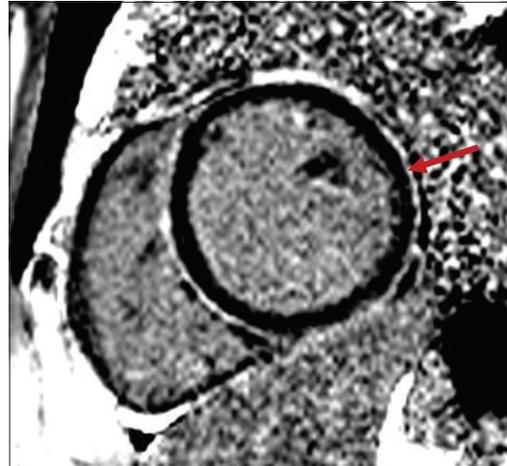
A 40-year-old male with 1 year history of shortness of breath and severe left ventricular systolic dysfunction on echocardiogram. Cardiac magnetic resonance late gadolinium image, short-axis view showing a rim of mid-myocardial hyperenhancement (arrow).
